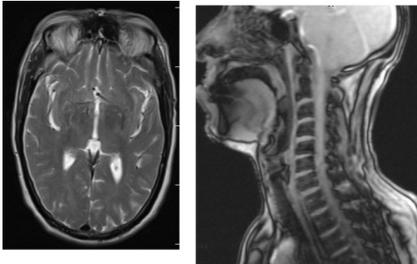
Cranial MRI and cervical MRI
